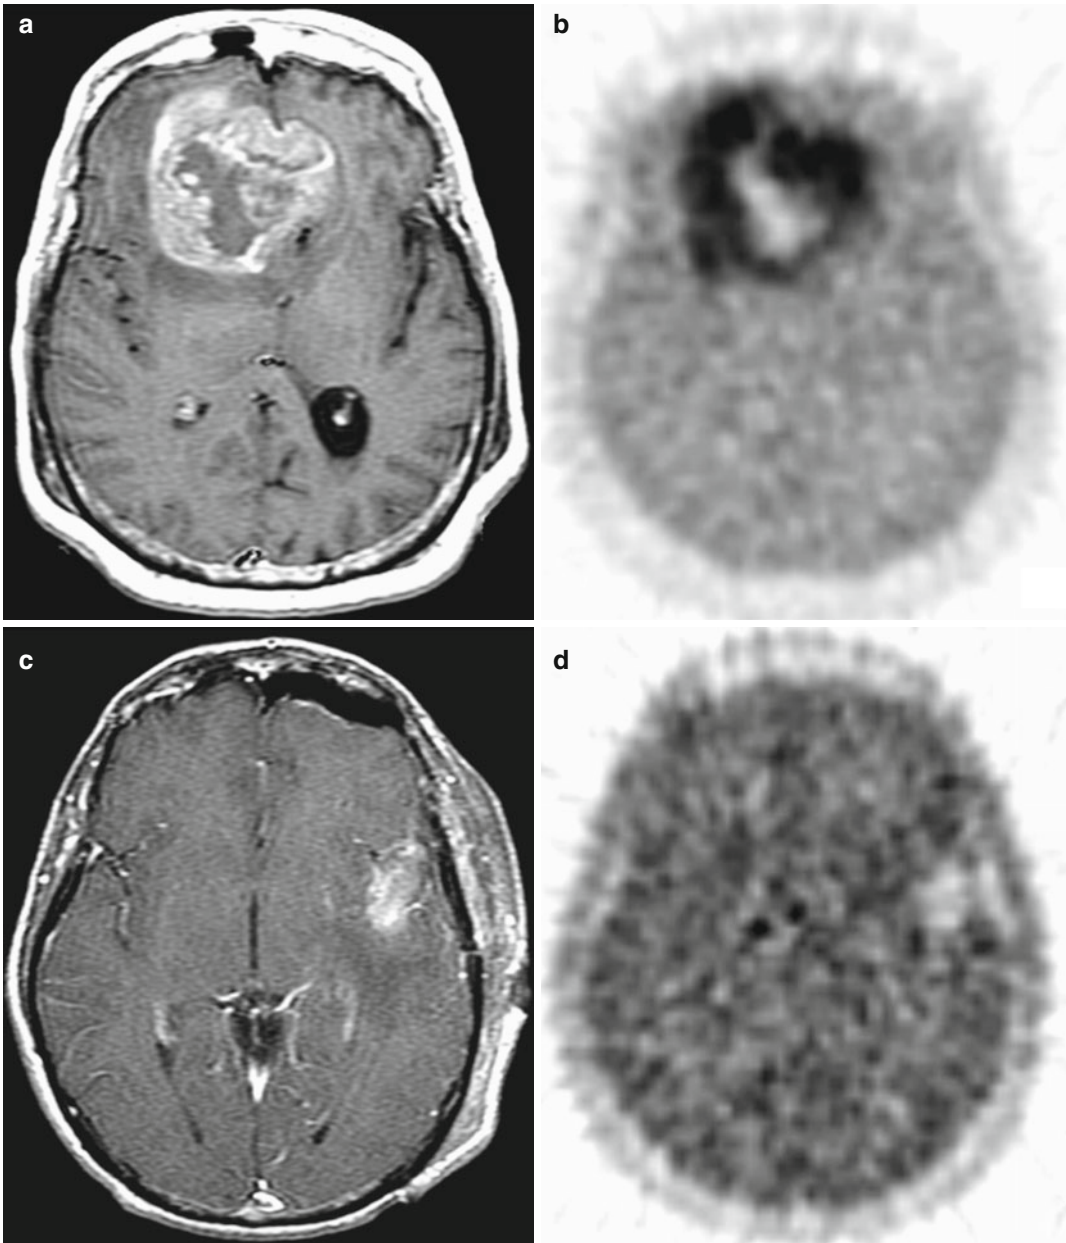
[^{18}F]FMISO accumulation has a predictive value. In patients with glioblastoma multiforme, the [^{18}F]FMISO uptake was assessed 2 h p.i. using PET scans before radiotherapy. Tumor-to-blood ratios >1.2 defined the hypoxic value. The burden of hypoxic tissue within the tumor is inversely related to time to tumor progression and survival. (a, c) The MRI T1Gd
